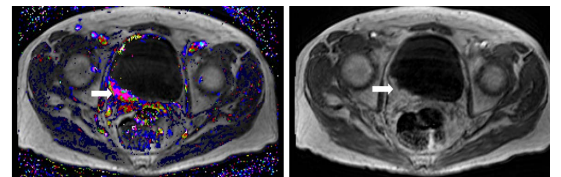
Left: Color map of exchange pharmacokinetic parameters Amp & Kep; Right: DCE-MRI image depicts the signal enhancement in the tumor region on a T1-weighted post-contrast image. The tumor is indicated by the arrows.
